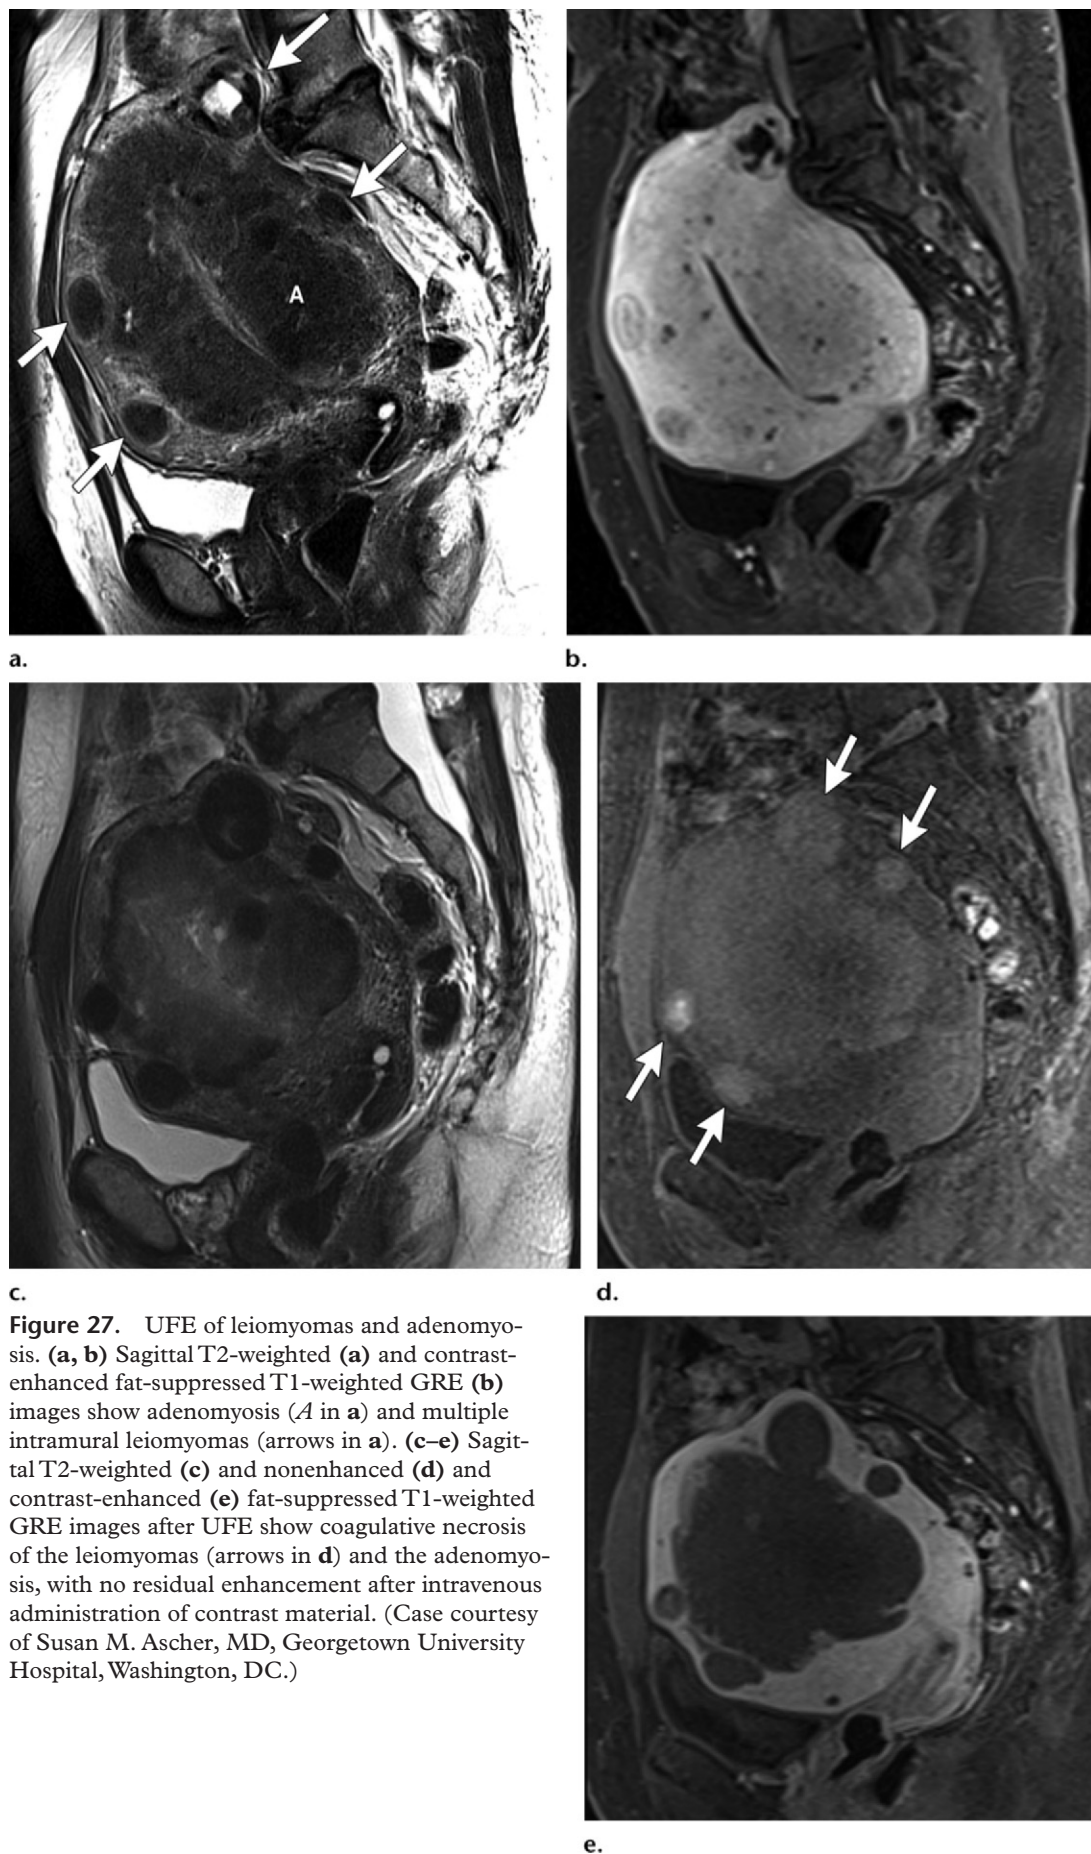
UFE of leiomyomas and adenomyosis. (a, b) Sagittal T2-weighted (a) and contrast-enhanced fat-suppressed T1-weighted GRE (b) images show adenomyosis (*A* in a) and multiple intramural leiomyomas (arrows in a). (c–e) Sagittal T2-weighted (c) and nonenhanced (d) and contrast-enhanced (e) fat-suppressed T1-weighted GRE images after UFE show coagulative necrosis of the leiomyomas (arrows in d) and the adenomyosis, with no residual enhancement after intravenous administration of contrast material. (Case courtesy of Susan M. Ascher, MD, Georgetown University Hospital, Washington, DC.)
